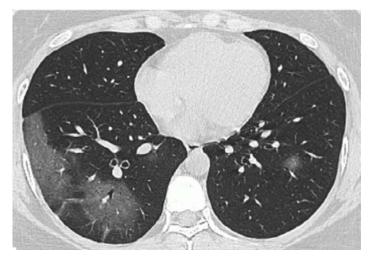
HRCT scan showing multiple ground glass opacities.
